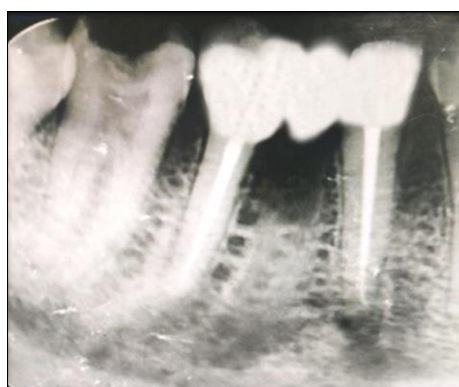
12 month follow up radiograph
